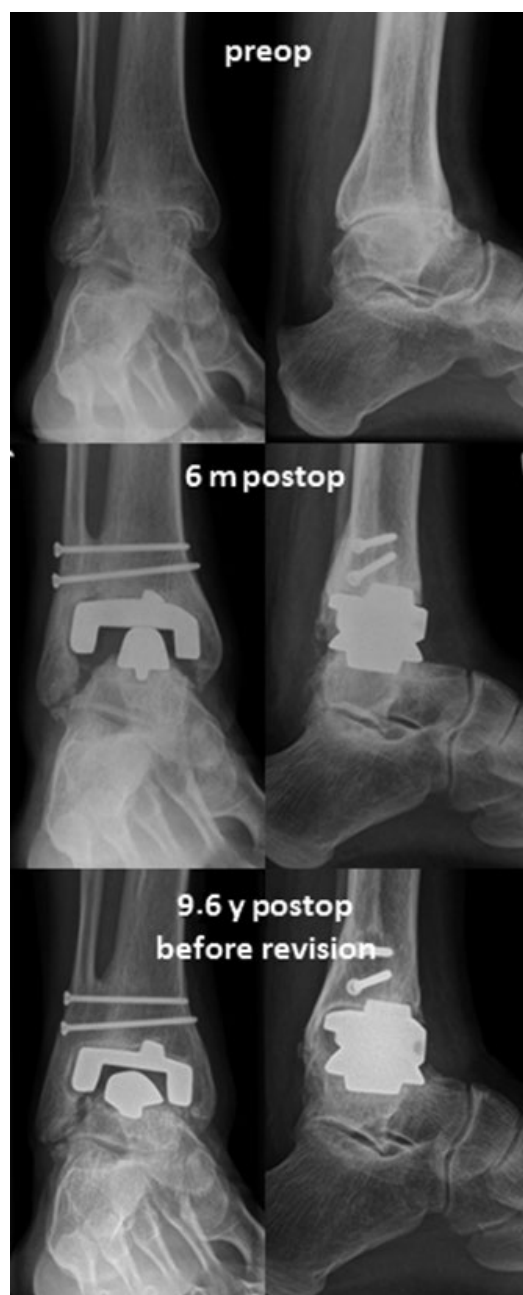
Serial radiographs of a patient with revision secondary to implant loosening 9.6 y after total ankle replacement implantation
